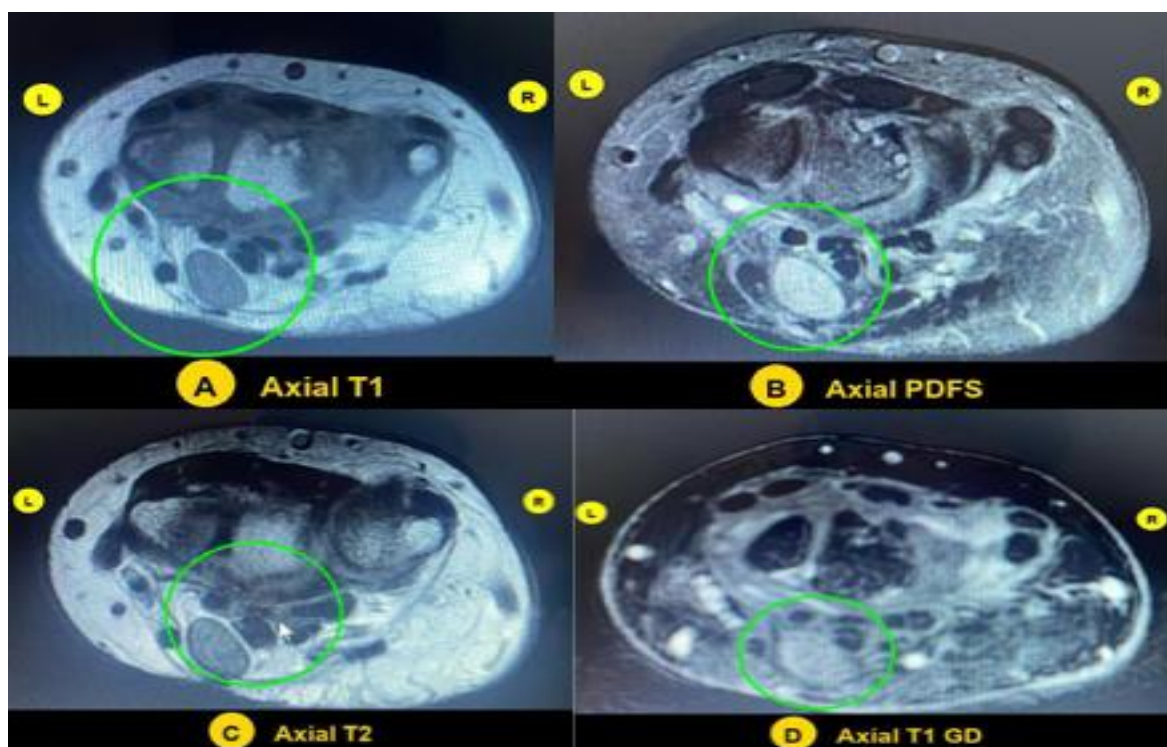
Patient came with complaints of pain, numbness, tingling sensation, and weakness. Case shows MRI of the right wrist joint. The Axial T1 (A), Axial PDFS (B), Axial T2 (C), and 3D Axial GD (D) sequences demonstrate Carpal Tunnel Syndrome. There is median nerve flattening at the carpal tunnel level with significant nerve thickening (increased cross-sectional area) and loss of the normal fascicular pattern at the carpal tunnel inlet. This is also accompanied by a mild loss
